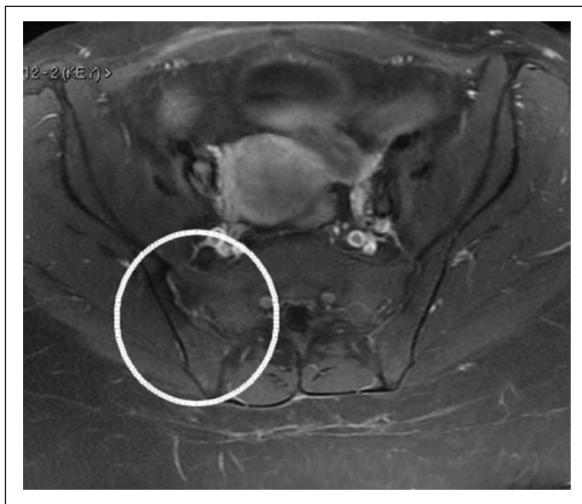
A pelvic MRI a year later revealed normal bone marrow signal and normal surrounding muscle. There are no fluids within the joints.
